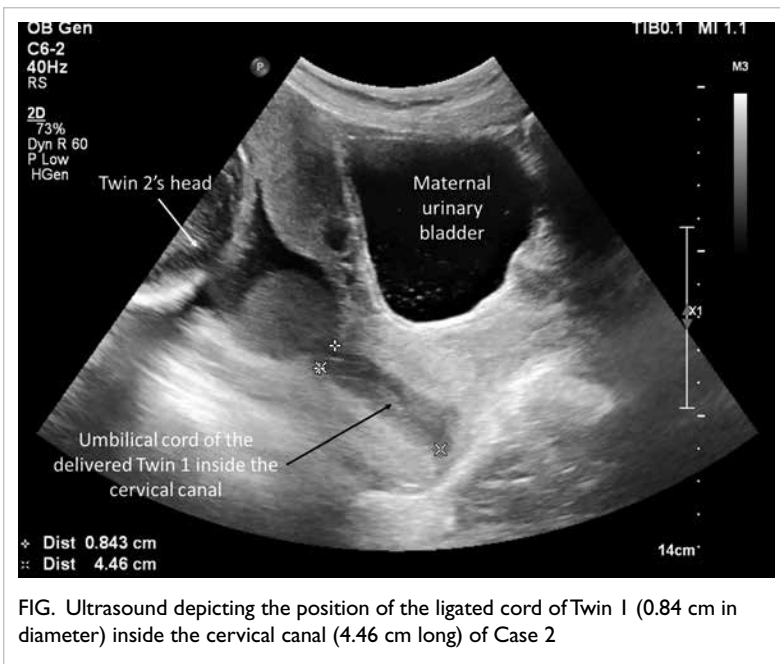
Ultrasound depicting the position of the ligated cord of Twin 1 (0.84 cm in diameter) inside the cervical canal (4.46 cm long) of Case 2
